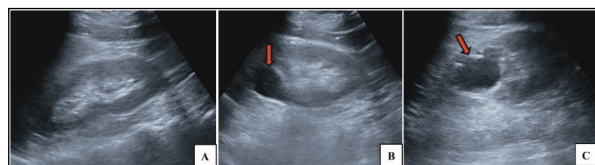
(A-C): Ultrasonographic images of bilateral kidneys. Longitudinal ultrasonographic images of the right (A) and left (B and C) kidneys reveal normal appearing right kidney (A) and focal ectasis of the upper polar calyces (red arrows) of the left kidney (B and C)
